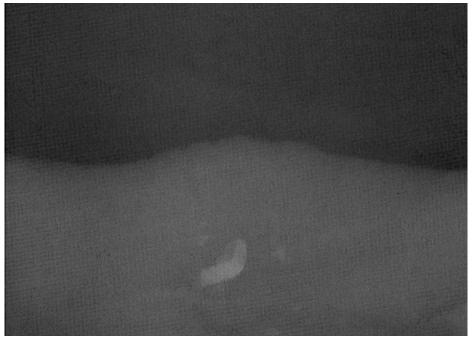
The soft tissue radiograph shows the radiopaque images of tooth fragments in the lip
